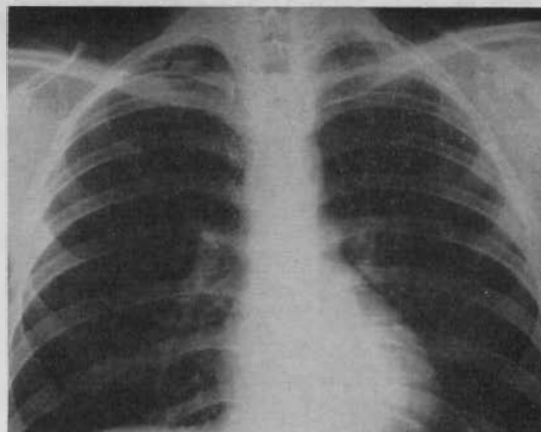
CASE V. Density noted in upper lobe of the left lung was detected with routine roentgenogram of the chest.
